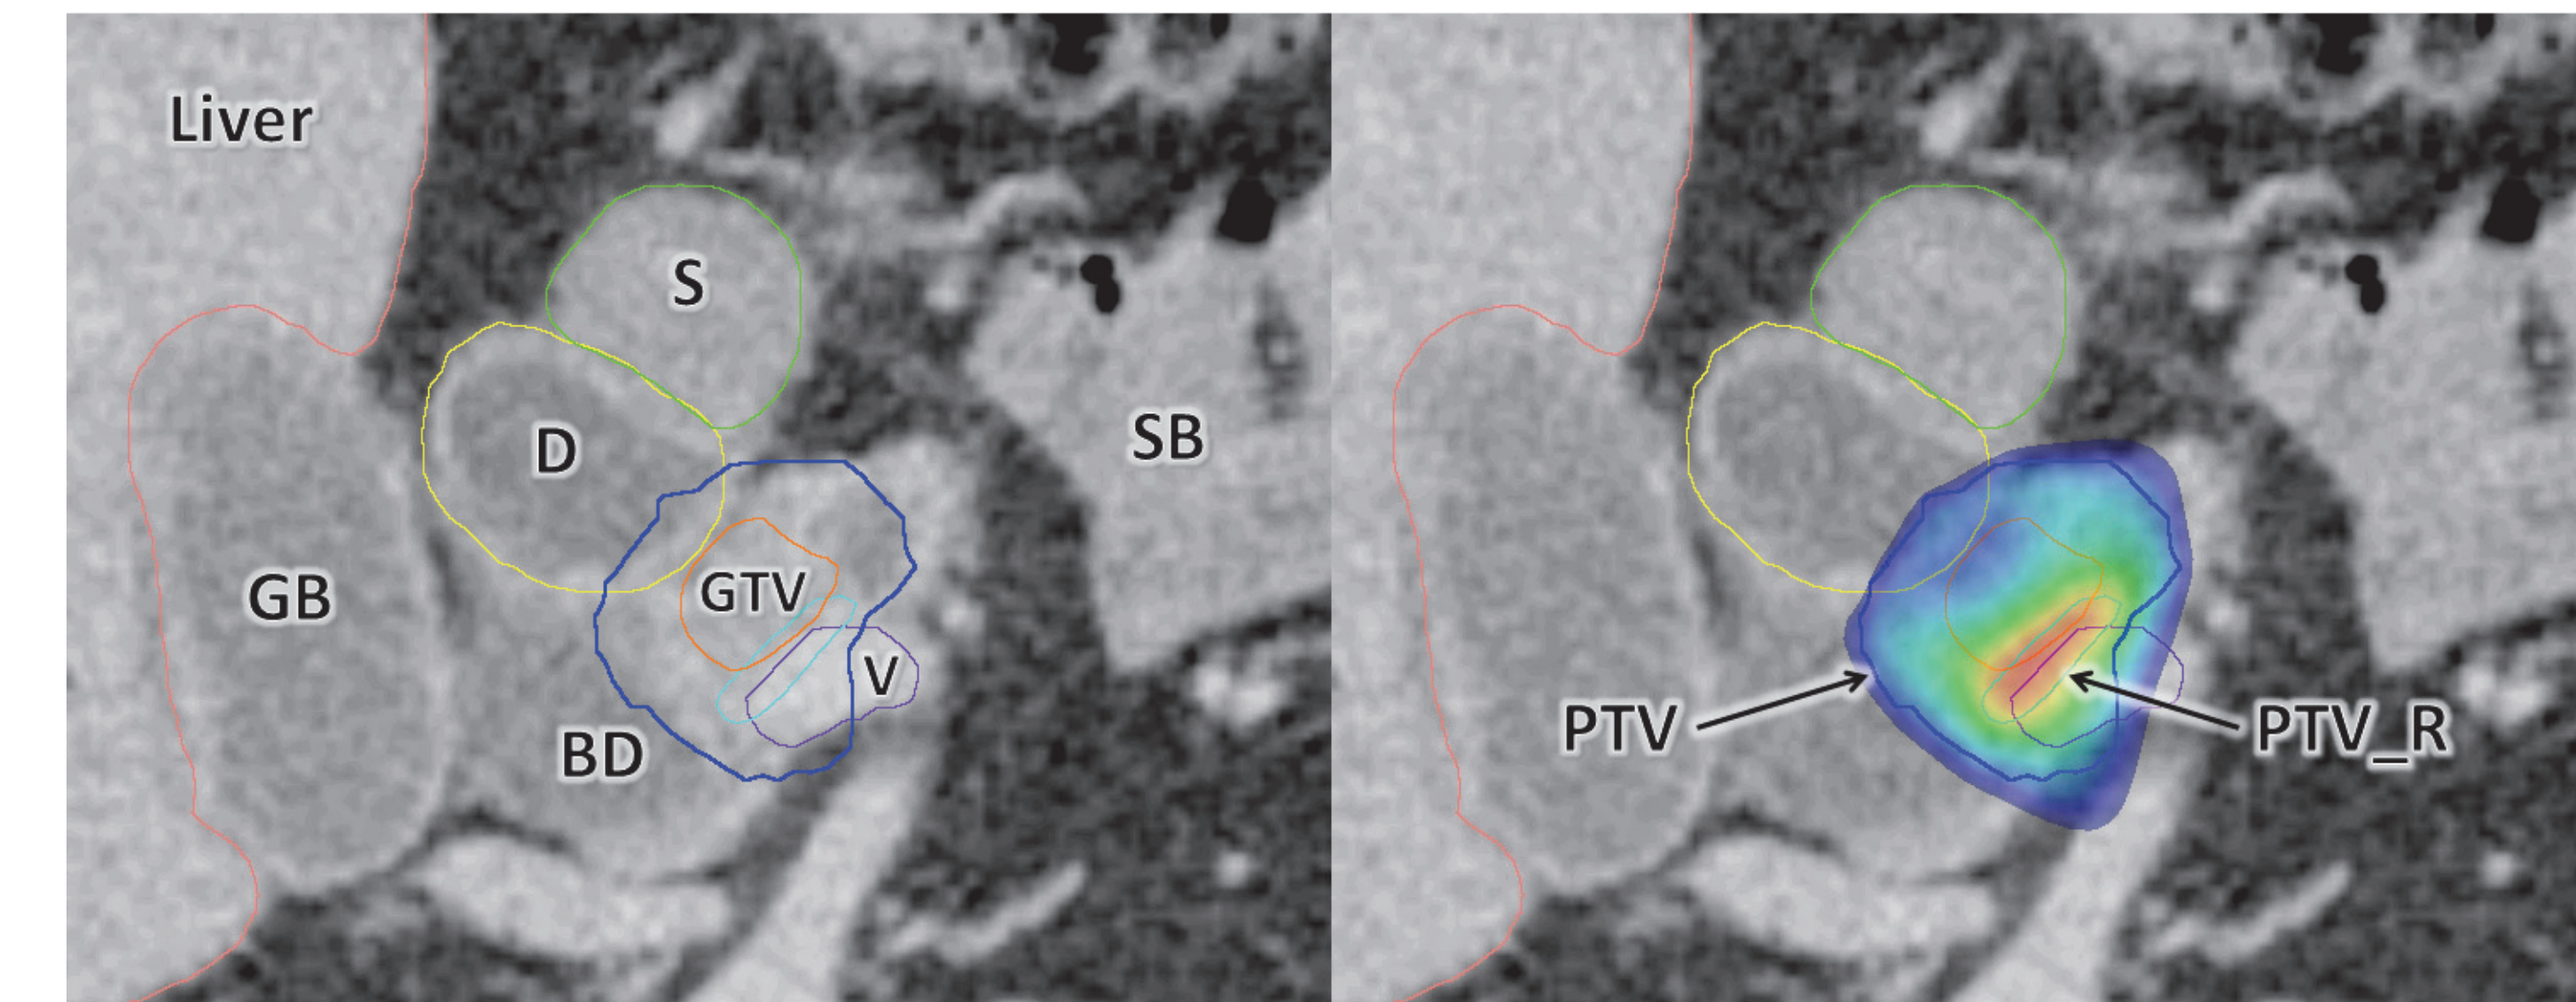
Planning CT of patient with borderline-resectable pancreatic cancer (BRPC). Left -: (clockwise) GB = gall-bladder, D = duodenum, S = stomach, SB = small-bowel, V = vessel in contact with tumour, GTV = Gross Tumour Volume, BD = bile duct. Right - radiotherapy plan dose colourwash PTV_R (boost volume, light blue contour), and PTV (dark blue)
